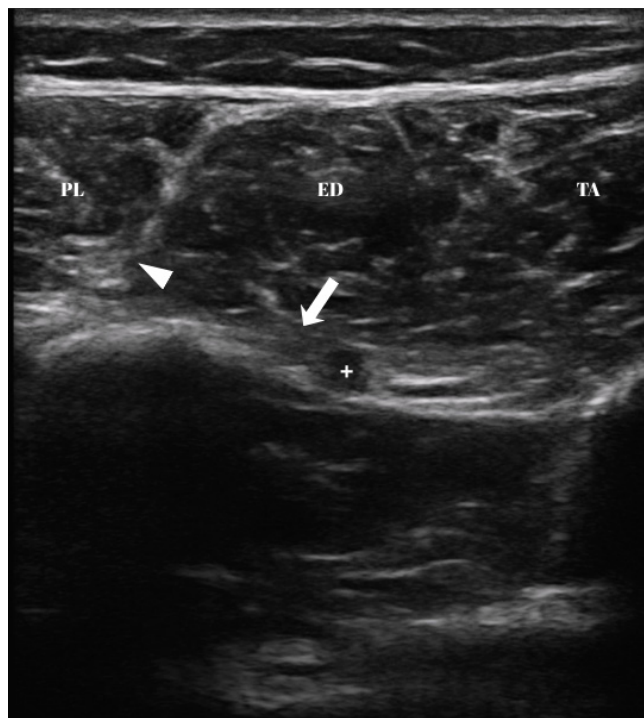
Short-axis ultrasound image at the distal peroneal tunnel. The white arrowhead indicates the superficial peroneal nerve, the white arrow indicates the deep peroneal nerve, and the plus sign (+) marks the tibial artery. PL – peroneus longus muscle; ED – extensor digitorum muscle; TA – tibialis anterior muscle
